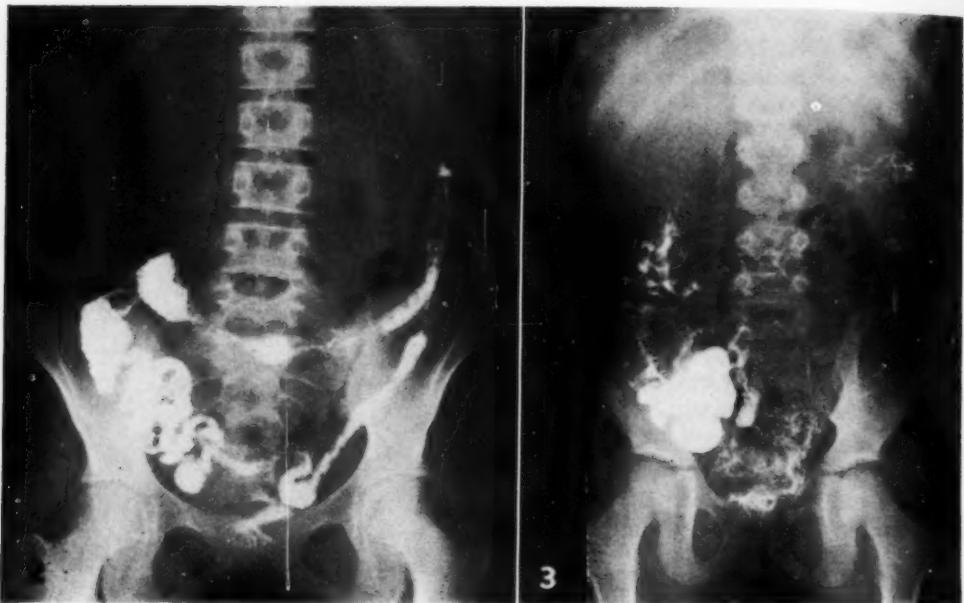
Post-evacuation roentgenogram of colon of a 14-year-old child, with shortening, narrowing, and loss of mucous membrane relief pattern in the entire colon. These are the characteristic roentgen changes of advanced chronic ulcerative colitis.
